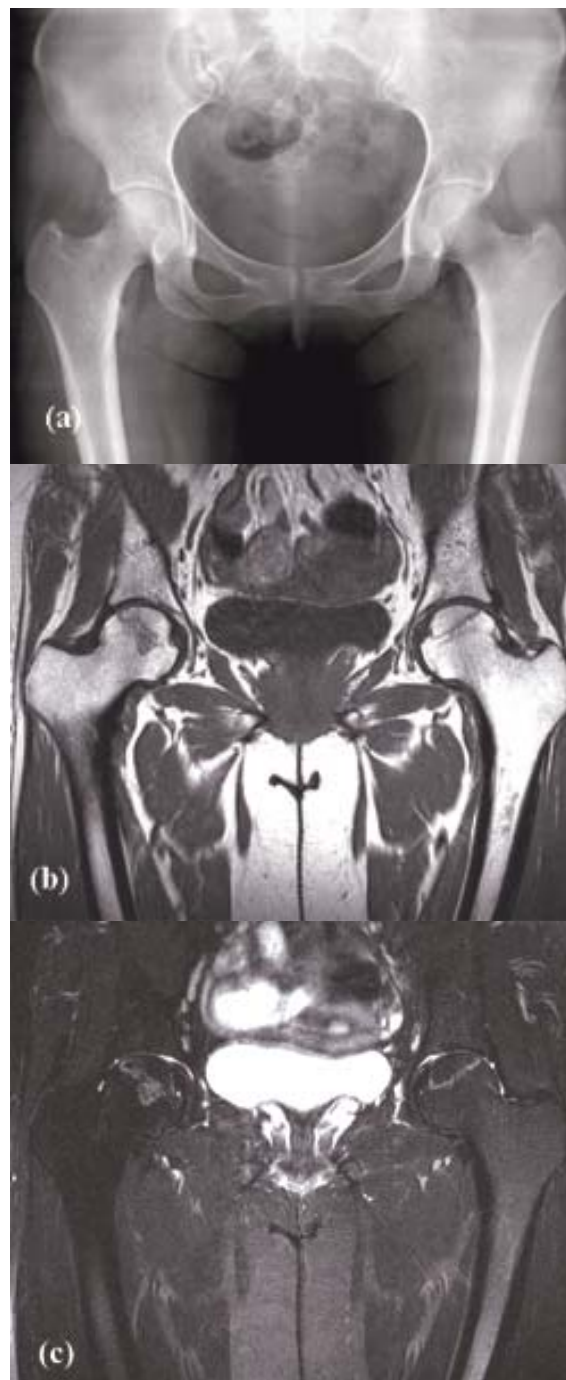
Patient 2: (a) AP radiograph of the pelvis shows normal appearance of both hips. (b) Coronal T1W and (c) T2WFS images show bilateral AVN. On the right, it was defined as grade 2 by which the lesion extends beyond the epiphyseal region, and involves less than half of the rest of the femoral head. On the left, it was defined as grade 1 due to the lesion confined within the epiphyseal region
